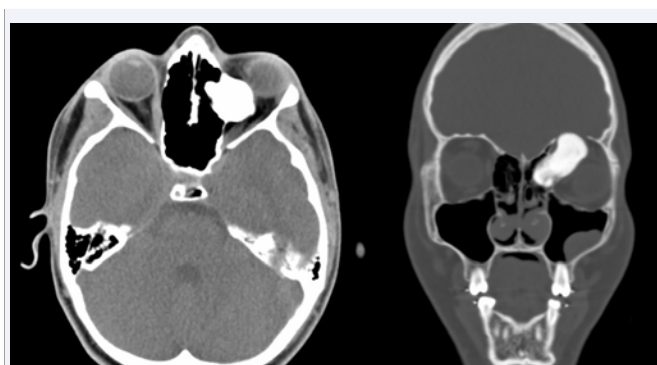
Maxillofacial CT without contrast, axial and coronal cuts, demonstrating uniform, bony mass originating from ethmoid sinus and extending through super medial left orbit.
